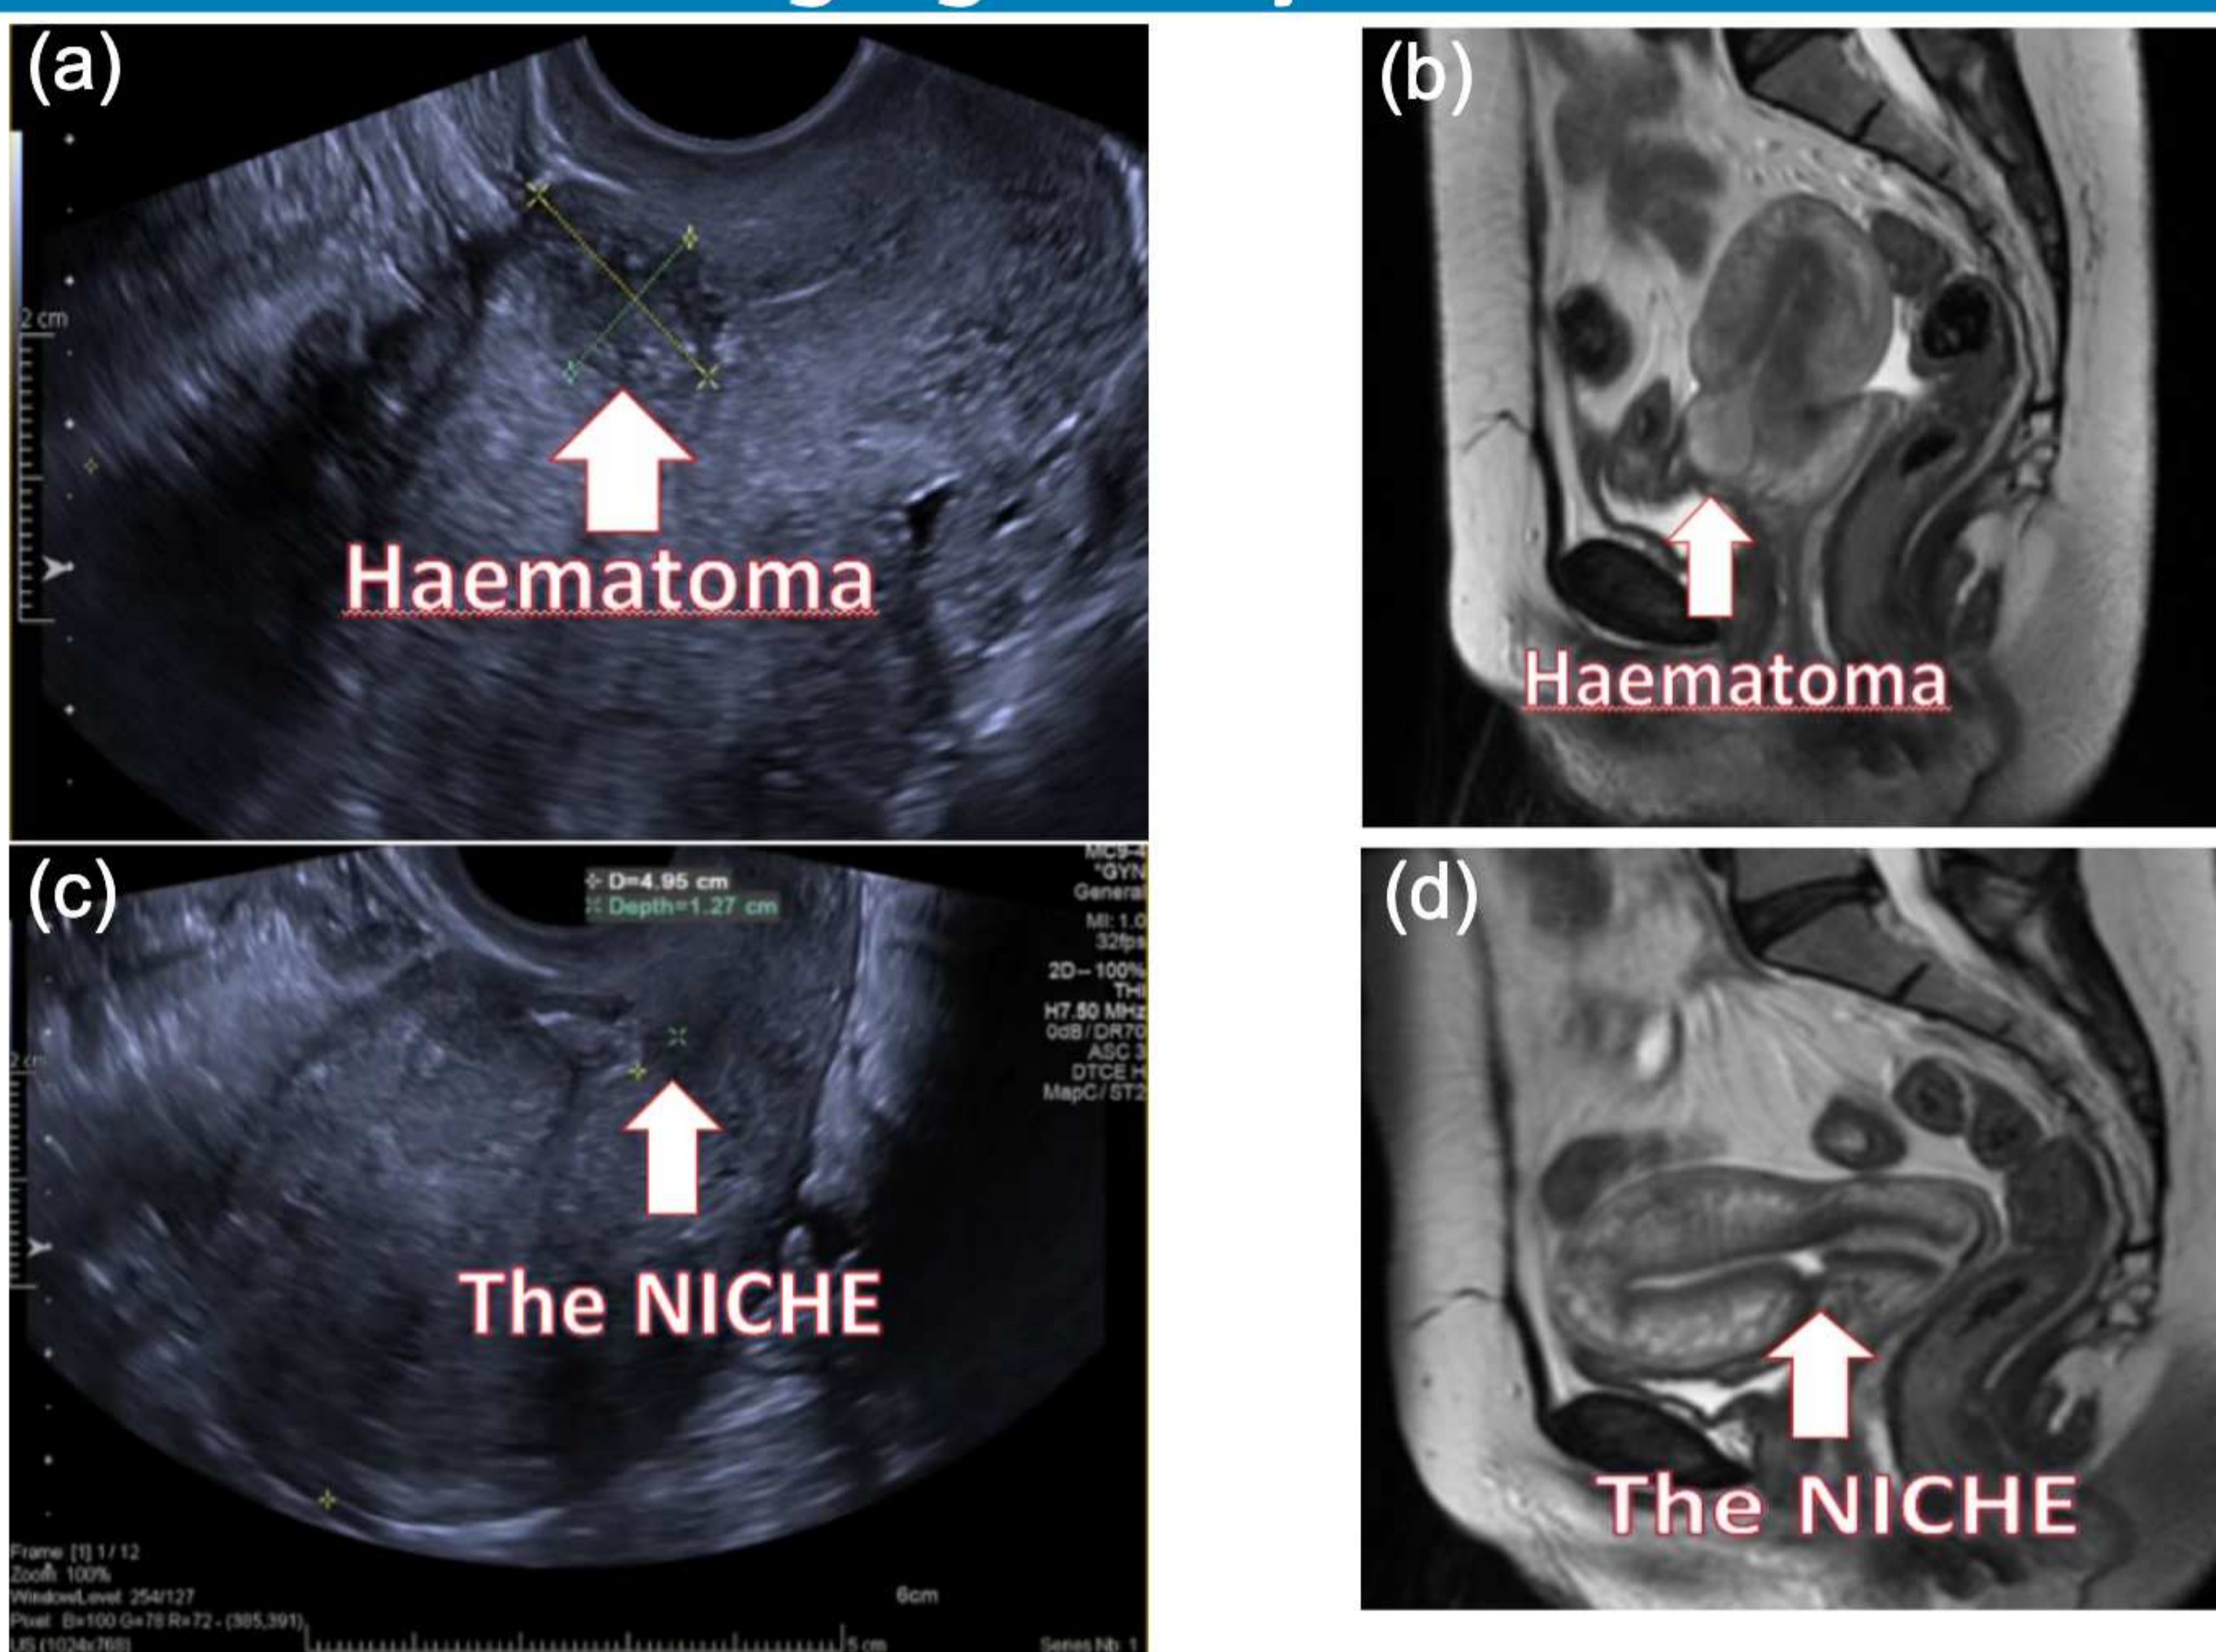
Image (a) and (b) - Haematoma in close relation to the NICHE observed on ultrasound scan and MRI scan in 2016, respectively. Image (c) and (d) - Disappearance of haematoma with visible NICHE remaining after conservative management, observed on ultrasound scan and MRI scan in 2018, respectively.
